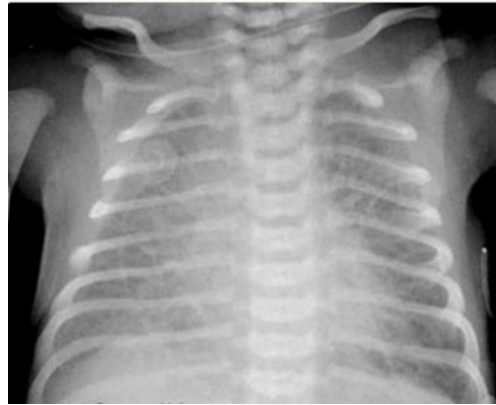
Transient tachypnea of the newborn is characterized by streaky, pulmonary interstitial markings and fluid in the fissure apparent on chest radiograph ⁽⁵⁾
